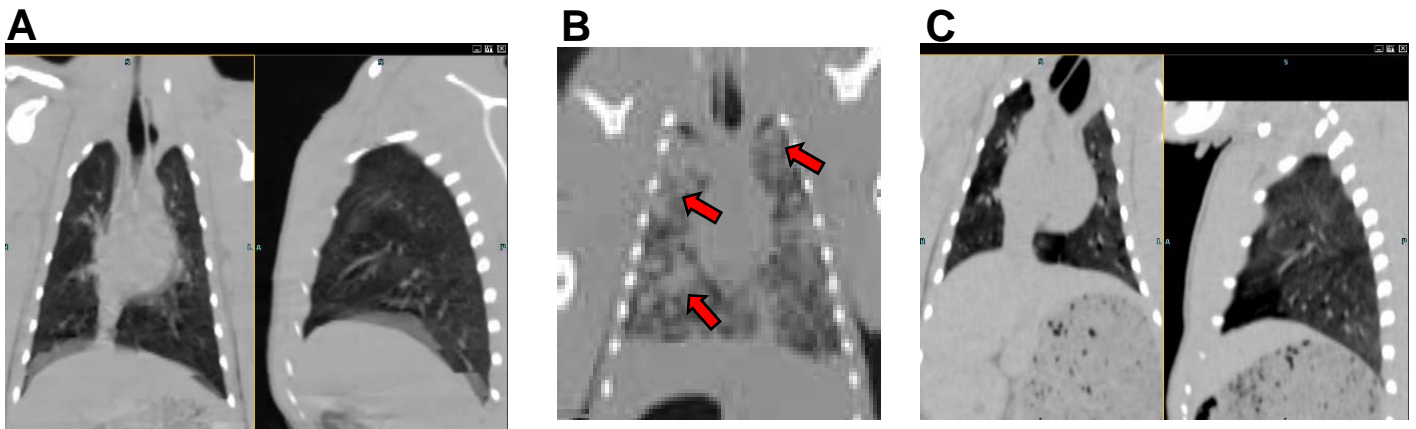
CT scans. NHPs were subjected to CT scan on day 42 (naïve and vaccinated) (A) and on day 88 (3 days post WT CO92 challenge) for the control NHPs (B) or day 167 (82 days post WT CO92 challenge) (C) for the immunized ones. The coronal and sagittal images of the lungs and their surrounding areas from representing NHPs were shown with the resolution of 512×512 pixels. The image sharpness was optimized to soft tissue. The arrows indicated consolidation patches in the lungs of a representative infected control NHP.
